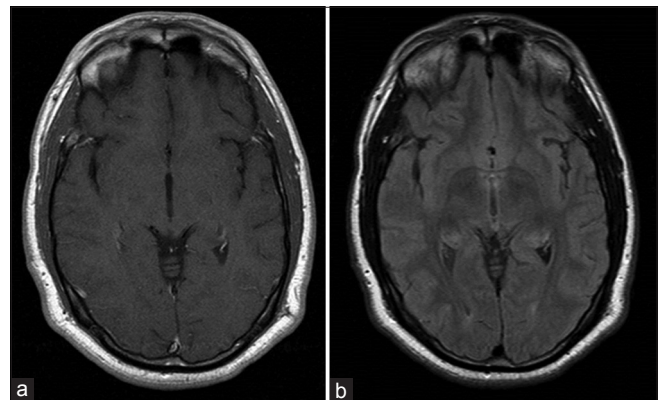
MRI after antibiotic treatment, 15 weeks post-discharge showing complete resolution of the previous tectal mass, without evidence of edema or hydrocephalus. (a) Axial T1 with contrast; (b) Axial FLAIR
